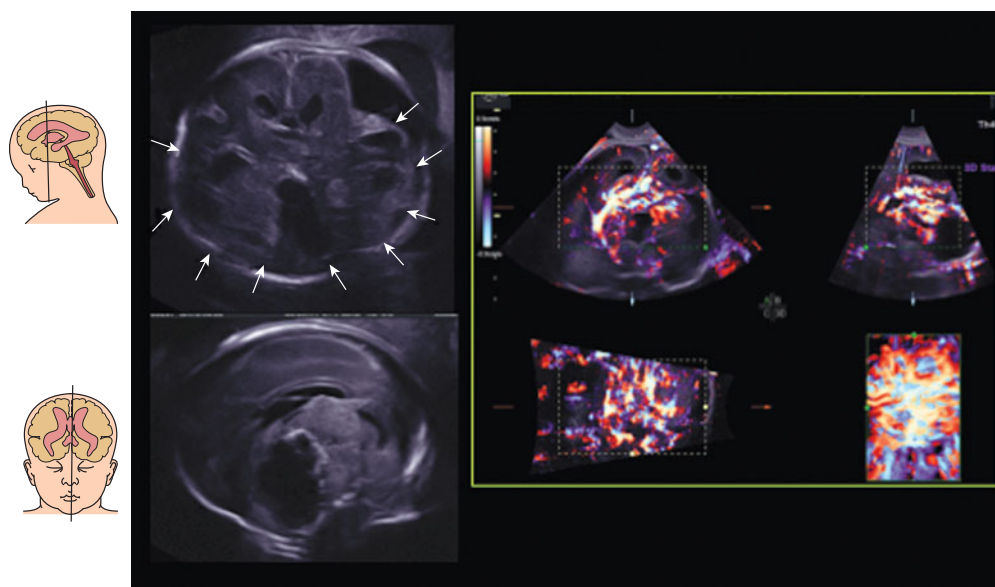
Brain tumor at 24 postmenstrual weeks of gestation. (A) 2D coronal section. A large mass (arrows) occupies the lower hemispheres. Between the cerebral hemispheres the tumor is not clearly defined. (B) 2D median section (right). The three orthogonal views and the reconstructed image of intratumoral vascularity by bidirectional power Doppler angiogram with the chaotic tumoral vessels are demonstrated.
